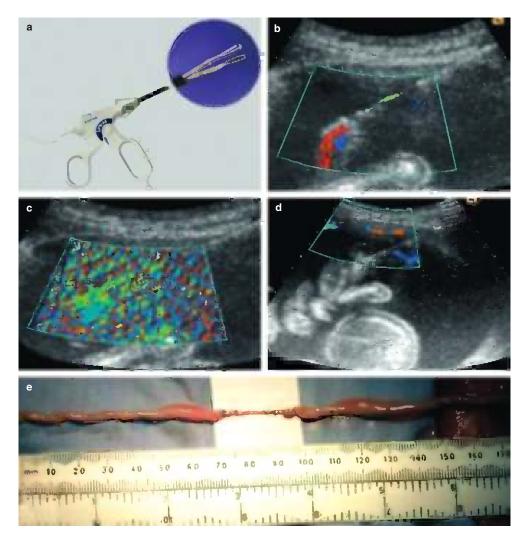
Instruments and technique for bipolar diathermy of umbilical cord. A 3-mm diathermy forceps (EverestTM) (a) is used to grasp the umbilical cord under ultrasound guidance after identification of the cord with color Doppler (b). Diathermy is applied (c), the cord is released and absence of blood flow through the cord is confirmed with color Doppler (d). Panel (e) shows the appearance of the umbilical cord of a selectively terminated recipient (cord occlusion by bipolar diathermy at 20 weeks) at delivery of the surviving donor at 35 weeks¹¹⁴. Reproduced with permission of John Wiley & Sons, Inc.
